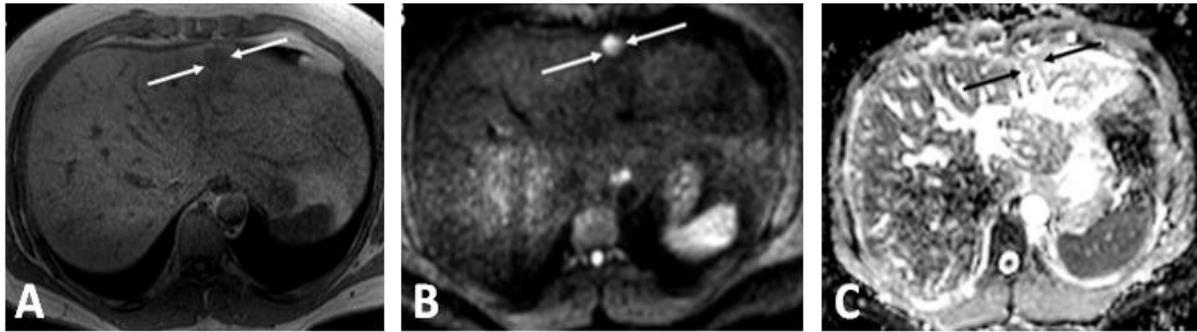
Thirty two year-old man with hepatic adenoma. A: Non-contrast T1weighted image shows low signal focal lesion (arrowed). B: The lesion (arrowed) shows high signal on DWI (b value = 300 sec/mm²). C: The lesion on ADC map shows intermediate signal (arrowed) with ADC value 1.690×10^{-3} mm²/sec.
